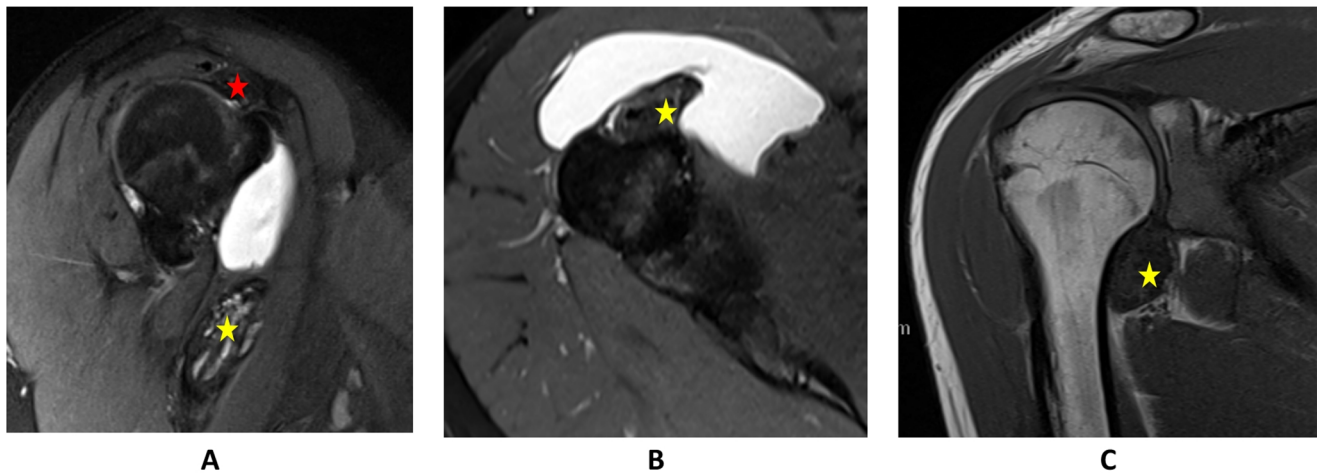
MRI scans of TGCT of the shoulder in patient 2. A: sagittal PD tse fs TE 47 of the right shoulder; B: axial PD tse fs TE 47 of the right shoulder; C: coronal T1 TSE of the right shoulder; The star marks the masses of TGCT around the biceps tendon (yellow) and subacromial (red)
